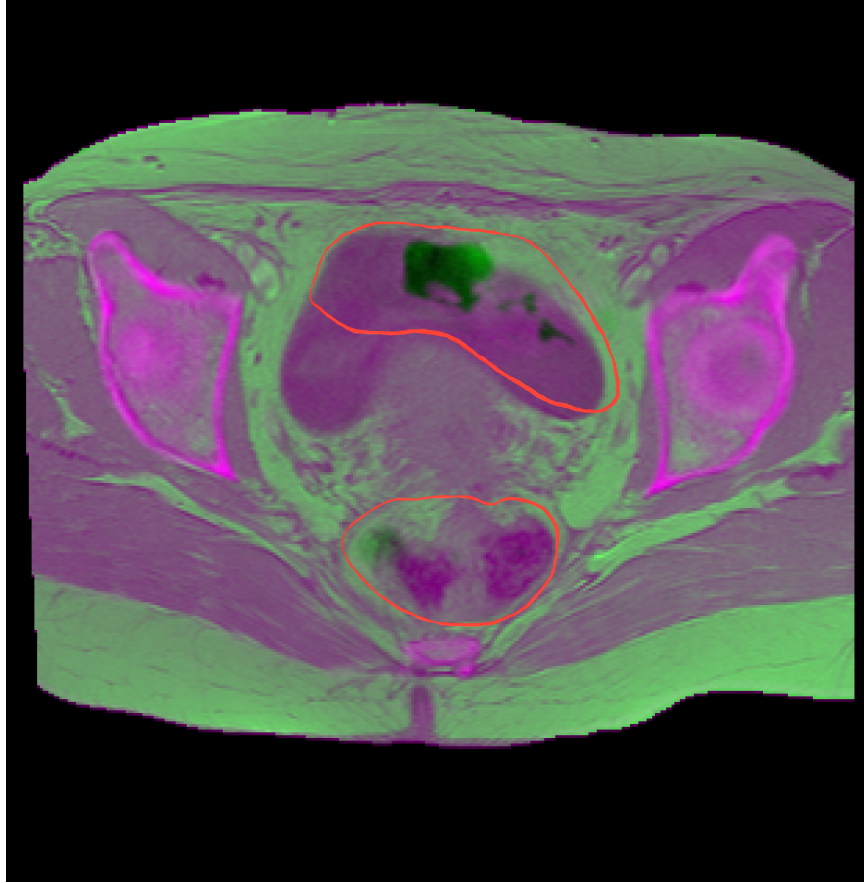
Example of a CT image (magenta) overlaid on the corresponding MRI image (green) with the excluded region shown inside the red contours.
